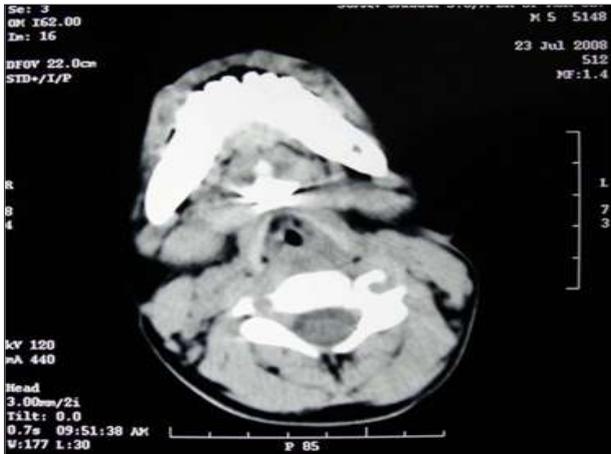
CT Sinography showing the sinus tract ending in front of the hyoid.
